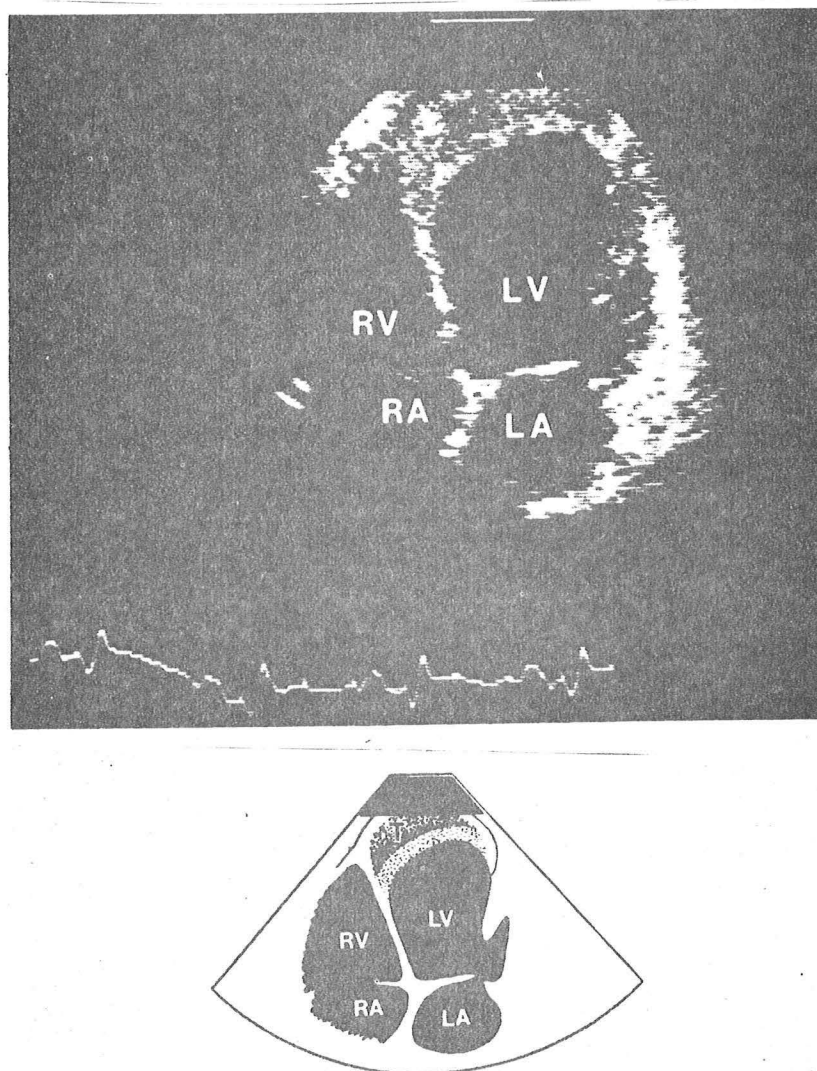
Apical, four-chamber, two-dimensional echocardiographic view of a left ventricular (LV) aneurysm with layered mural thrombus (T) (from Asinger et al⁵⁸).
